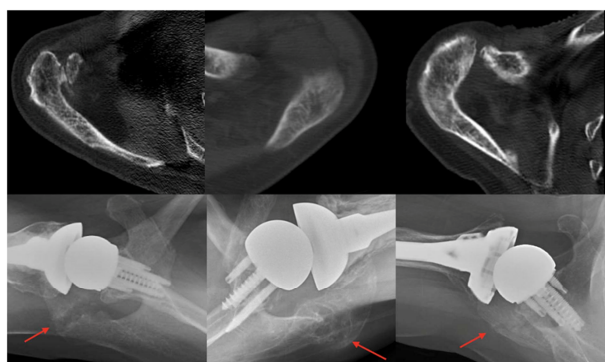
(Top) Initial negative CT scan and (Bottom) most recent axillary radiograph showing displaced non-united fractures. Red arrows indicate (left to right) Type 1, 2A, and 2B fractures.
